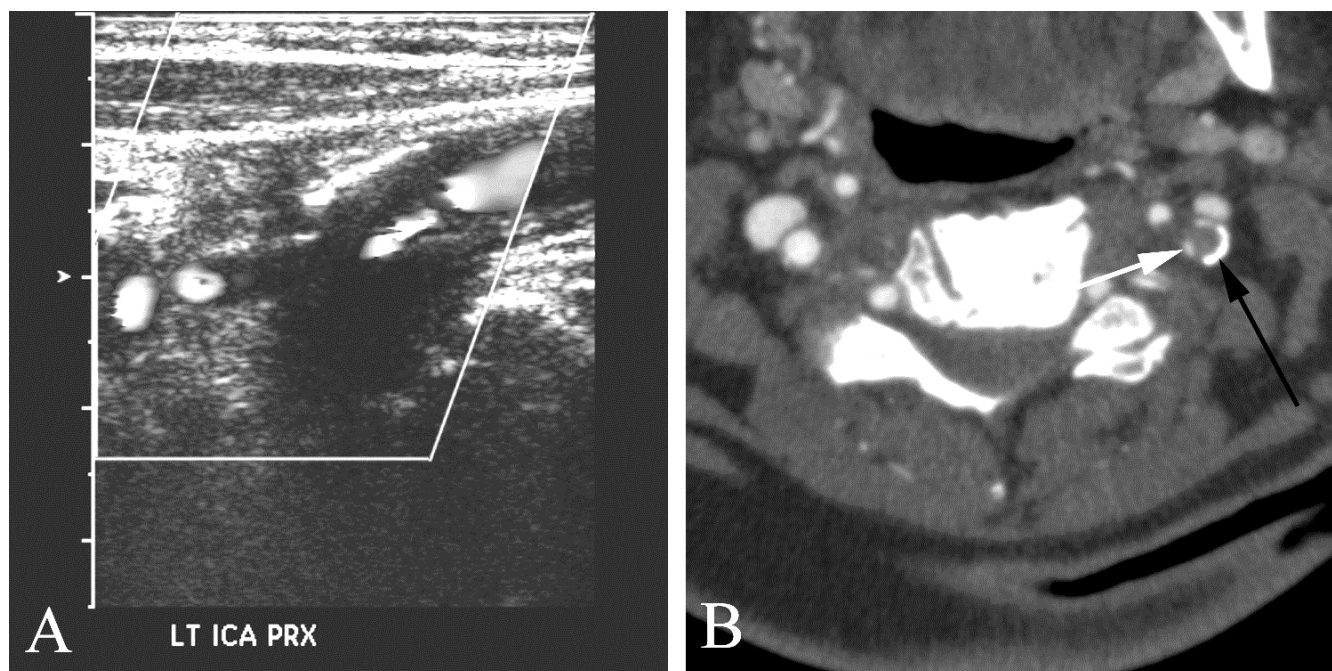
Severe left internal carotid artery stenosis in a 73 year old woman with an abnormal community screening result. A. Carotid US study shows dense calcification and severe stenosis of the proximal internal carotid artery. This was a diagnostic study done on the basis of the abnormal screening exam. B. Axial CT from a CT angiogram shows greater than
